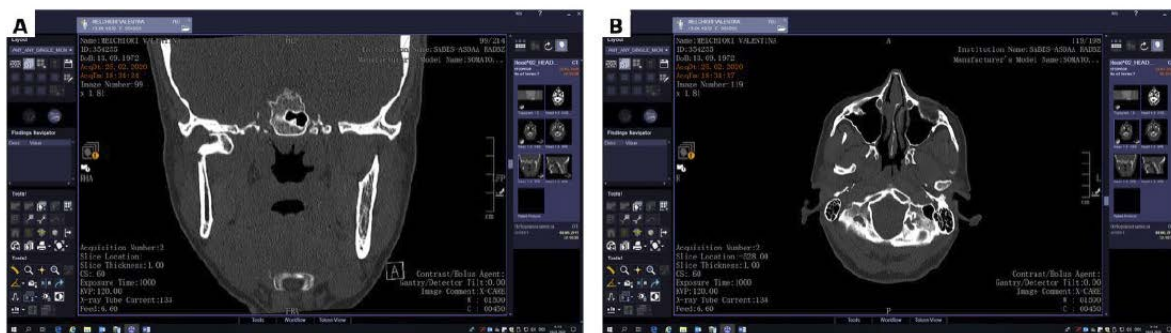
Preoperative cone-beam computed tomography (CBCT) of the right condylar fracture with medial dislocation. A, coronal view. B, axial view.
